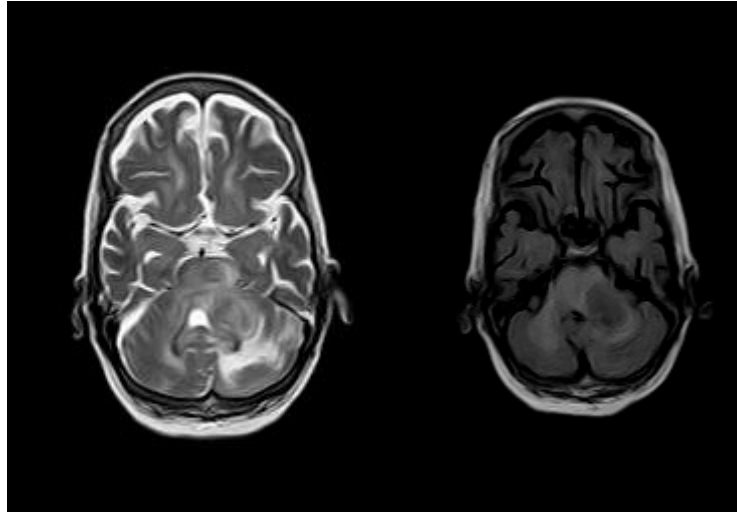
Axial T2/FLAIR: High signal in the left cerebellar hemisphere and middle cerebellar peduncle
